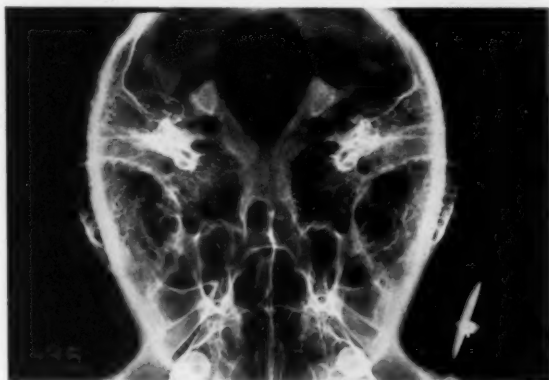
Reduced basal view Roentgenogram of adult Chimpanzee, showing extensive pneumatization of both temporal bones.
